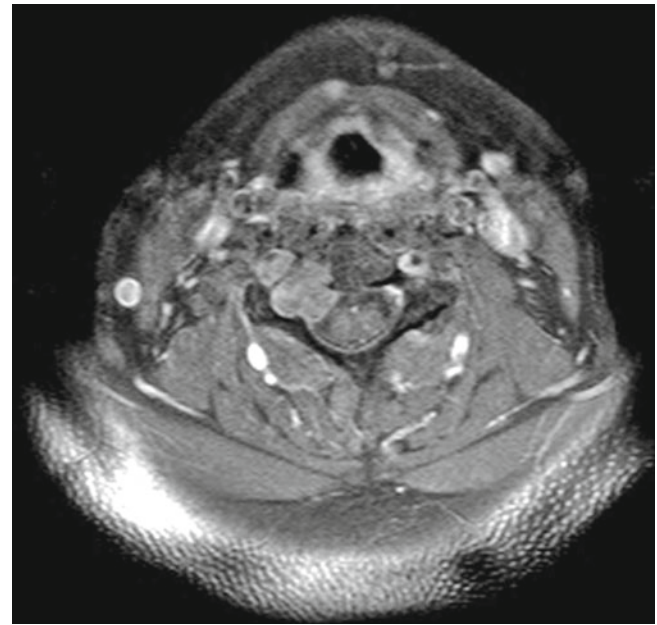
Typical MRI appearance of cervical spine chordoma, in this case involving right-sided pedicle
